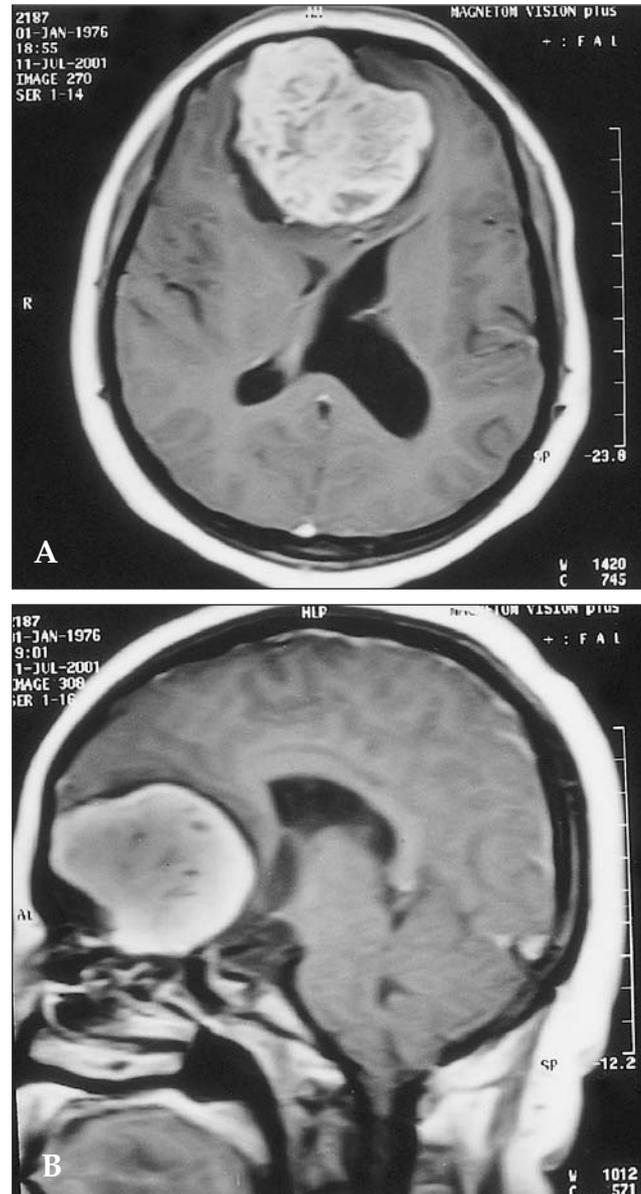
A, B: Axial and sagittal T1-weighted MRI. Gadolinium-enhanced image revealing a homogeneously enhancing extra-axial lesion located subfrontally in the anterior cranial fossa.
